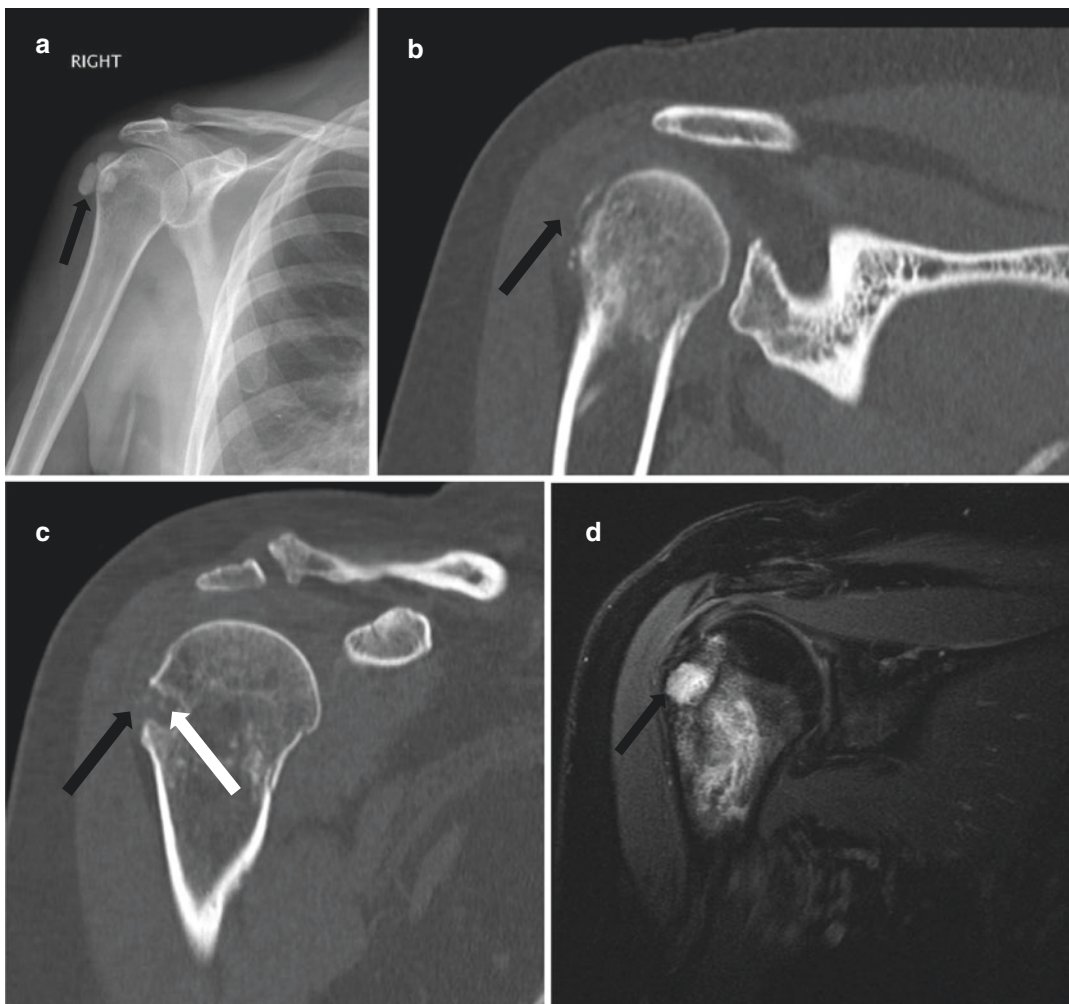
Calcific tendinitis with possible secondary osseous involvement. Frontal view radiograph of the right shoulder (a), sagittal reformatted CT images of the right shoulder (b, c), and coronal oblique fat-suppressed fluid-sensitive MR image (d) of the same patient. The CT and MRI images were obtained about 4 months later after the radiograph. Frontal radiograph A demonstrates globular HAD (black arrow) around the humeral head. CT of the right shoulder (b, c) approximately 4 months later
